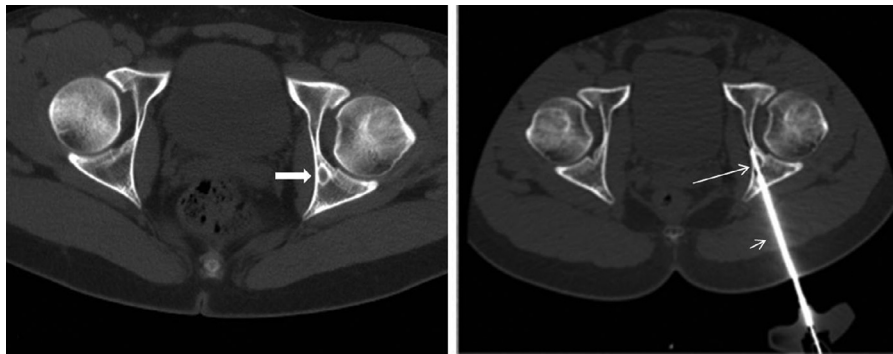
(a) Computed tomography image before the RFA procedure shows the hypodense nidus (thick arrow) surrounded by the sclerotic rim. (b) CT image during the ablation shows the active tip of the radiofrequency electrode (thin long arrow) inside the nidus of the OO advanced coaxially through the bone drilling needle (thin short arrow).
